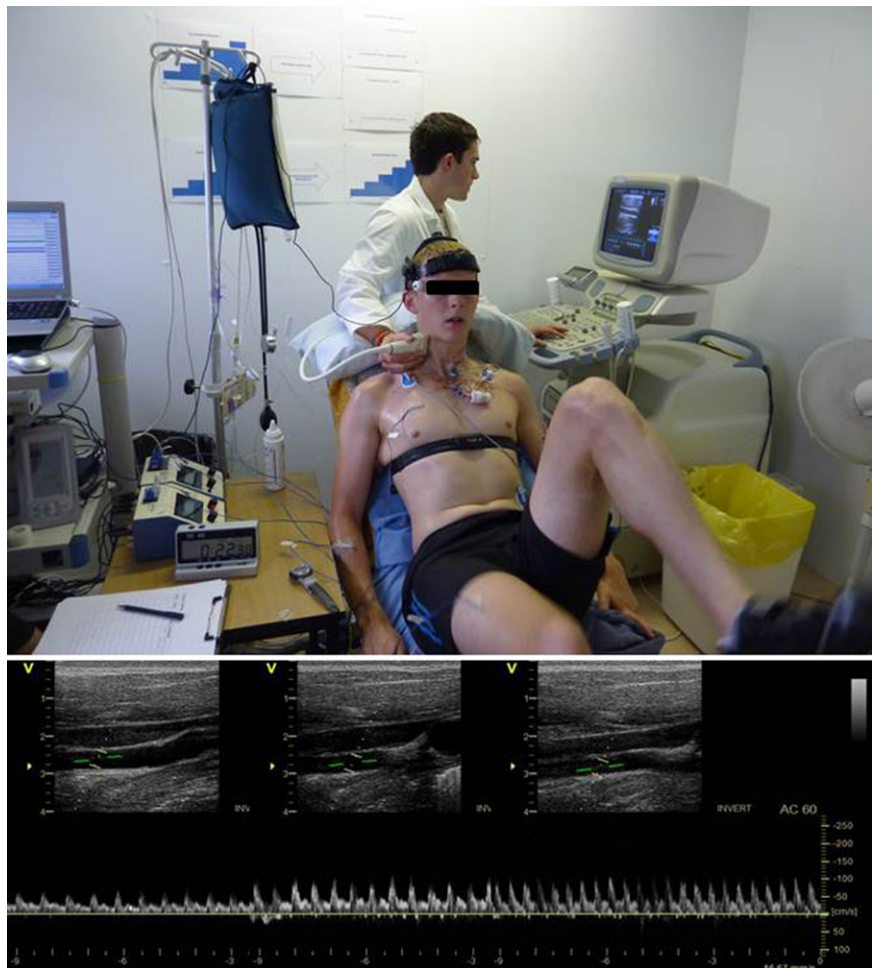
Experimental arrangement and ultrasound recording
